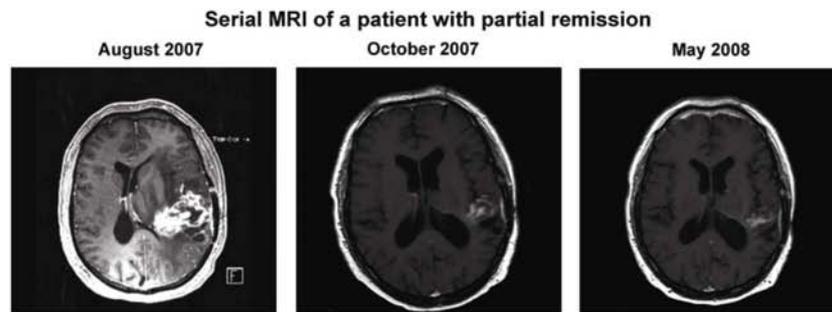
MRI scan of a 64-year-old man with a PR and a TTP of 342 days. The patient initiated treatment within 4 weeks of the MRI scan originating from August 2007.
